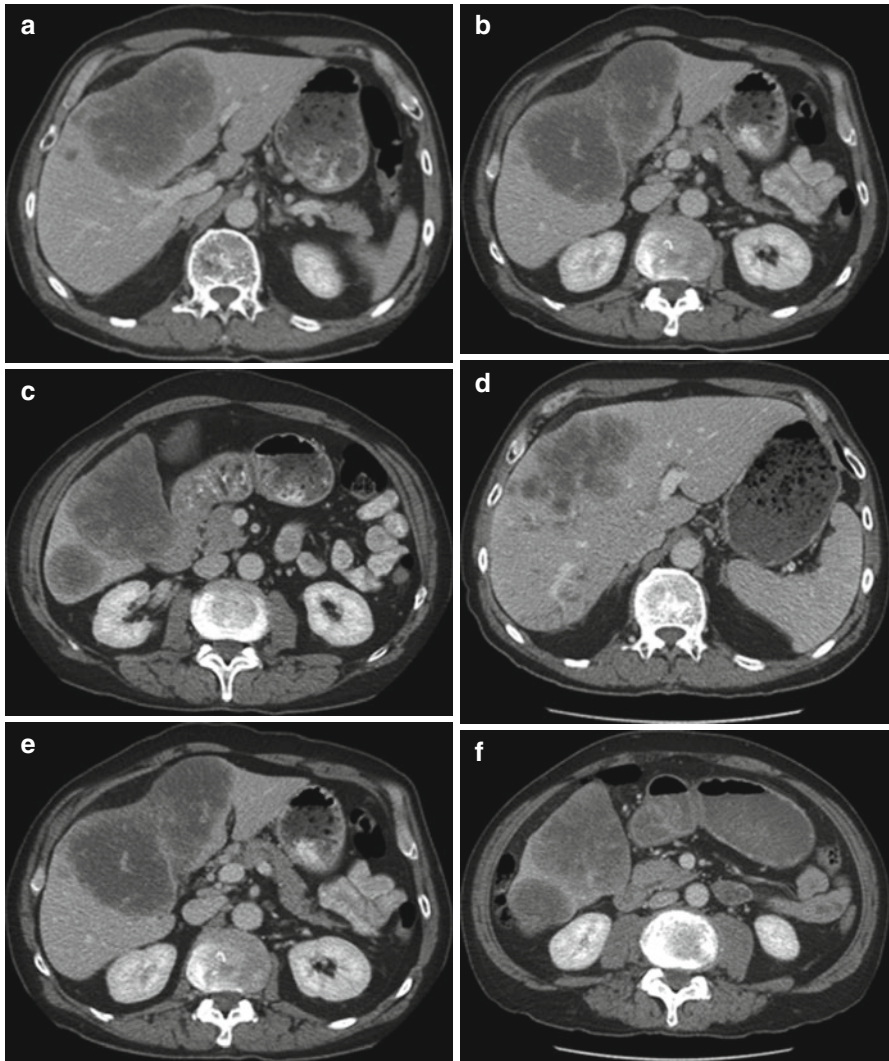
(a, b, c) Sequential CT scans demonstrating a large central metastasis requiring extended right hepatectomy. Segments 2 and 3, the future liver remnant, constitute 18 % of the hepatic volume. (d, e, f) Sequential CT scans of the same patient 21 days following right portal vein embolization. There has been atrophy of the right lobe and hypertrophy of the left lobe. Segments 2 and 3 now constitute 31 % of the hepatic volume. Extended right hepatectomy was undertaken without complication, and the patient was discharged from the hospital on day 5
